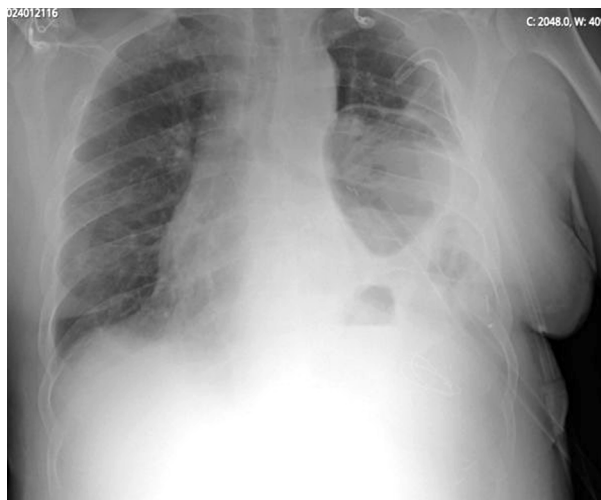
Chest radiograph on the second postoperative day.
